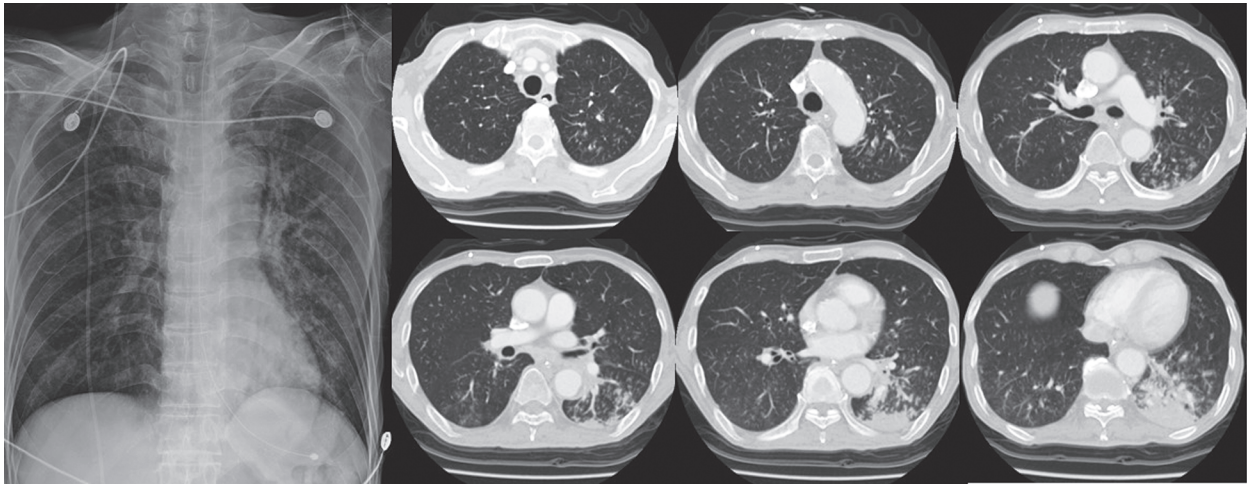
Initial chest radiography (left) and chest CT (right). A consolidation with air bronchograms at left lower lobe with suspected aspirated materials at left upper and lower lobar bronchus
